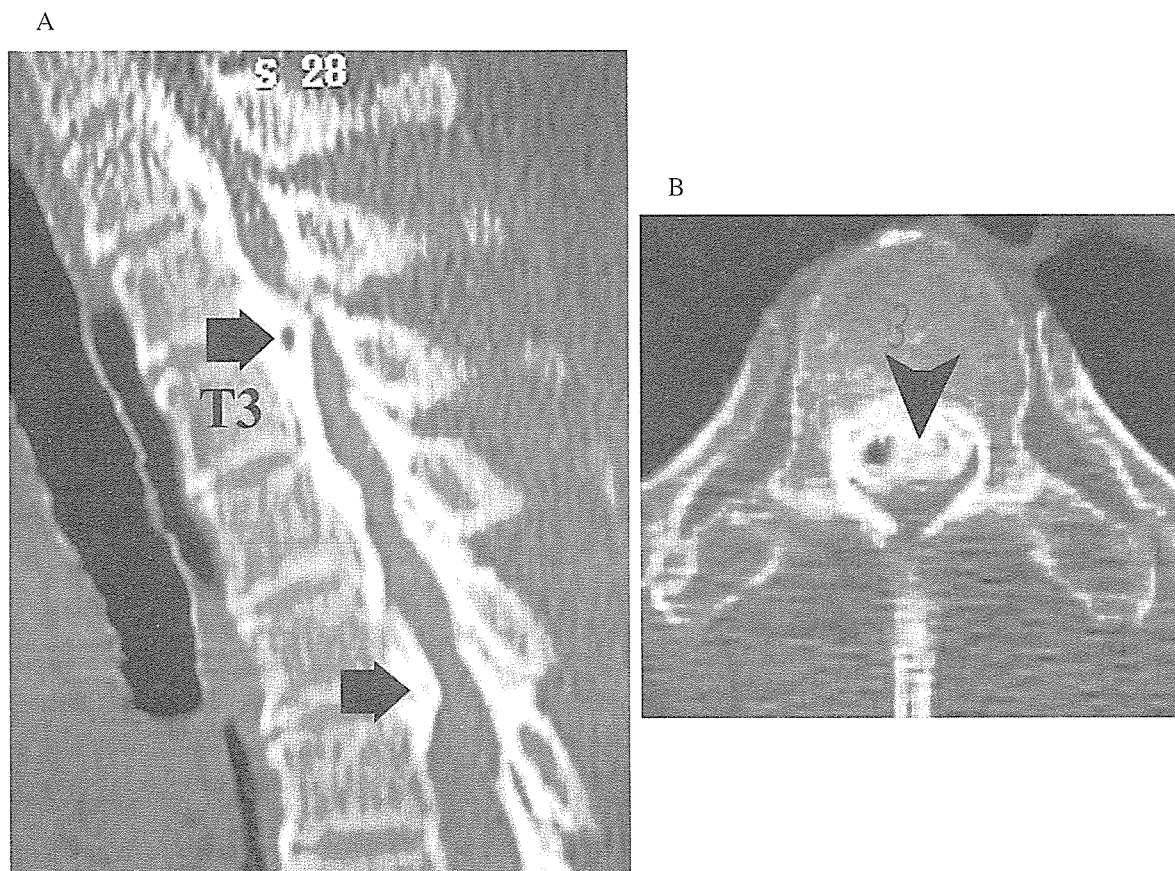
Preoperative CT of a patient with OPLL.
